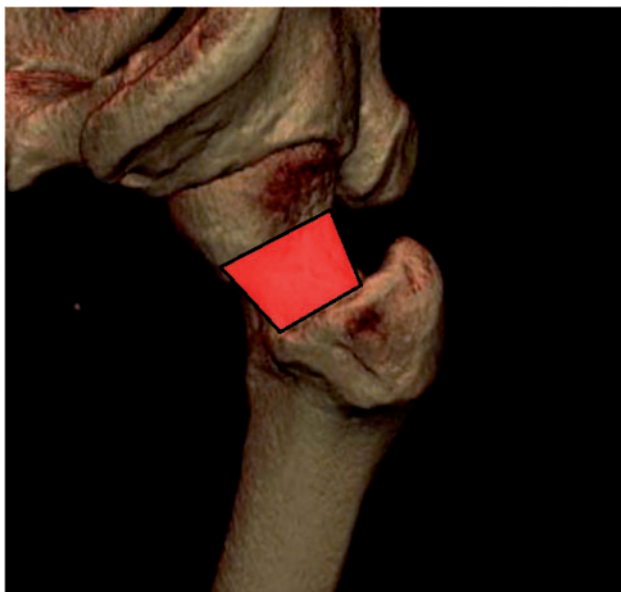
3D CT lateral view of hip. If the lesion is seen on the lateral view in the neck region (red rectangle) then it must be either the anterolateral head neck type or the anterolateral neck type. If a lesion is not present in the red rectangle it must be either the anterior head neck junction lesion or anterior neck lesion only.
